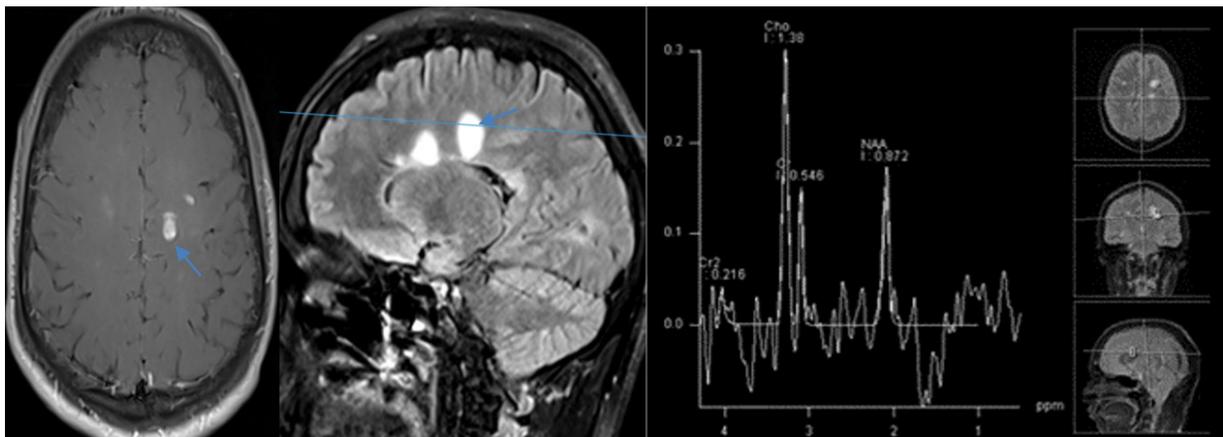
TIWI contrast axial, FLAIR sequence sagittal images showing lesion in the left centrum semi ovale measuring up to 1.9 × 1.6 cm with gadolinium-enhancement but no significant perifocal edema. MRS at the level of lesion showing elevated peaks of choline and lactate with mild reduction of NAA.
